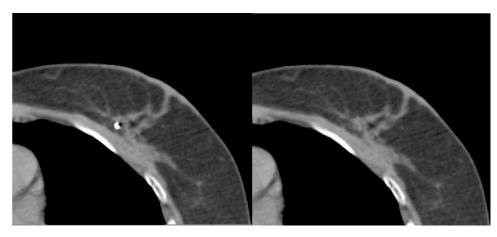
Axial CT slices showing surgical clip (left) and corresponding image after patch-based texture synthesis (right).
